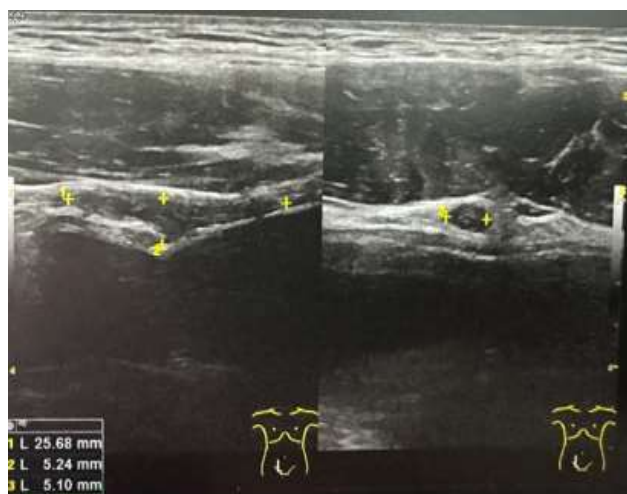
Ultrasound showing a patent urachus (between yellow crosses).
